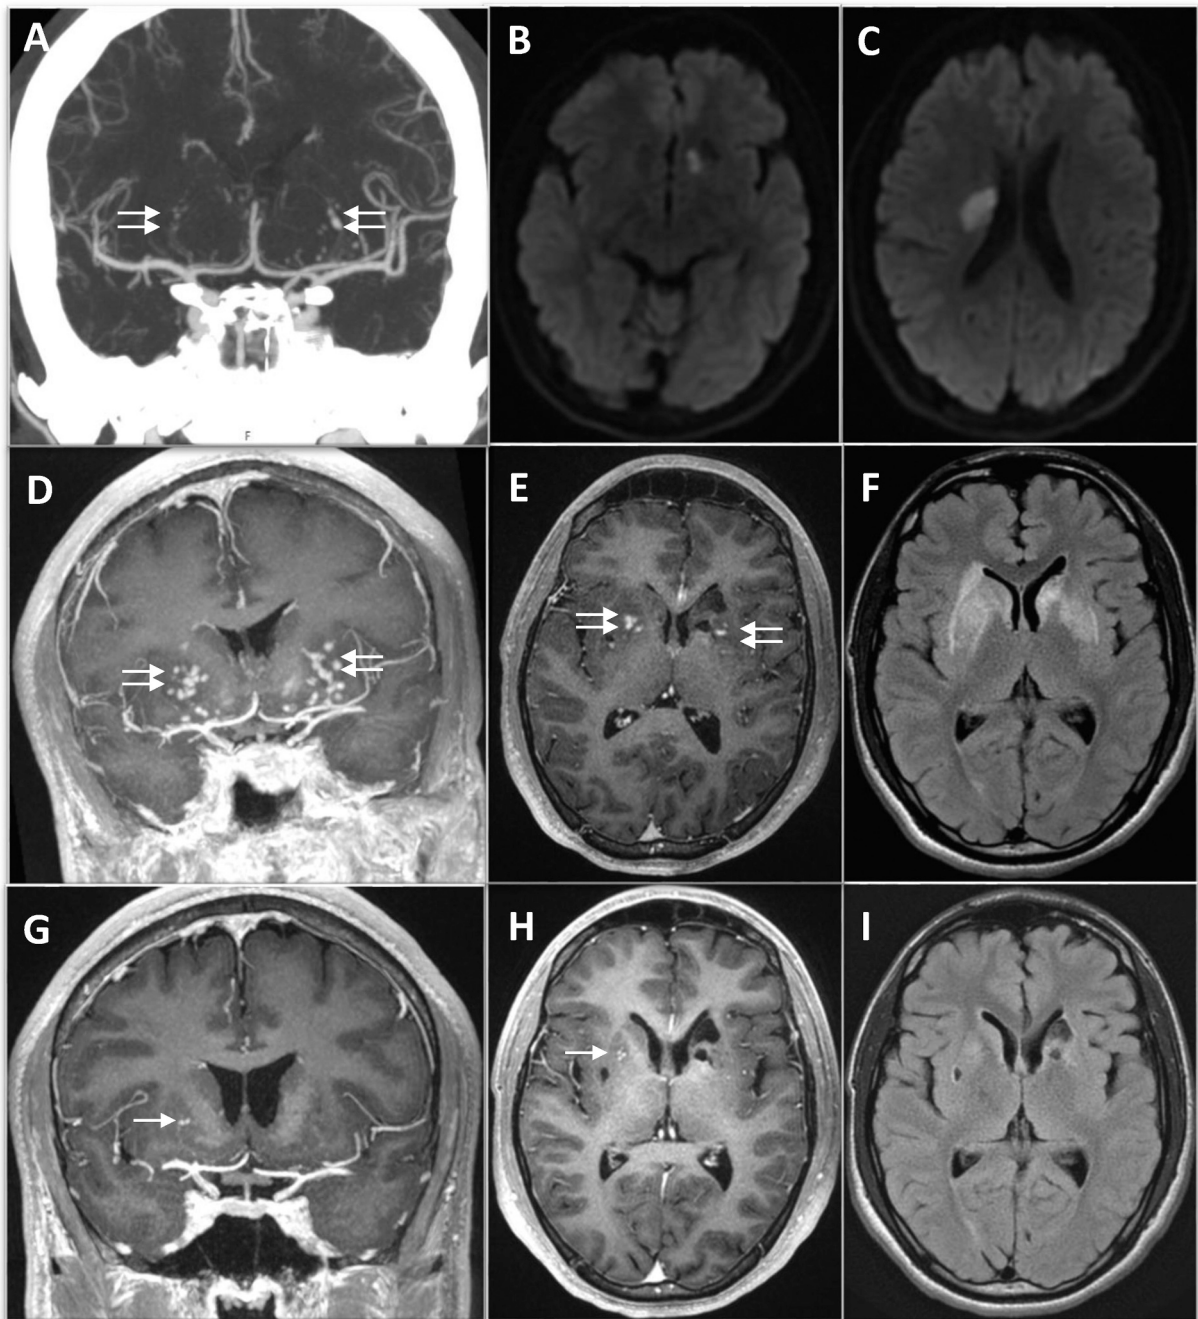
CT angiography and MRI showing cerebral infarction, lenticulostriate vasculopathy, and basal ganglia lesions in patient with COVID-19.
